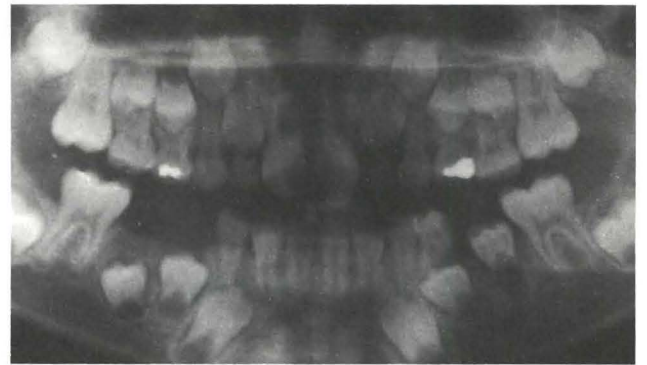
Panoramic radiograph of mandibular left second premolar with minimal root development in a stage of premature eruption. Note alteration of eruption sequence compared to contralateral arch.
